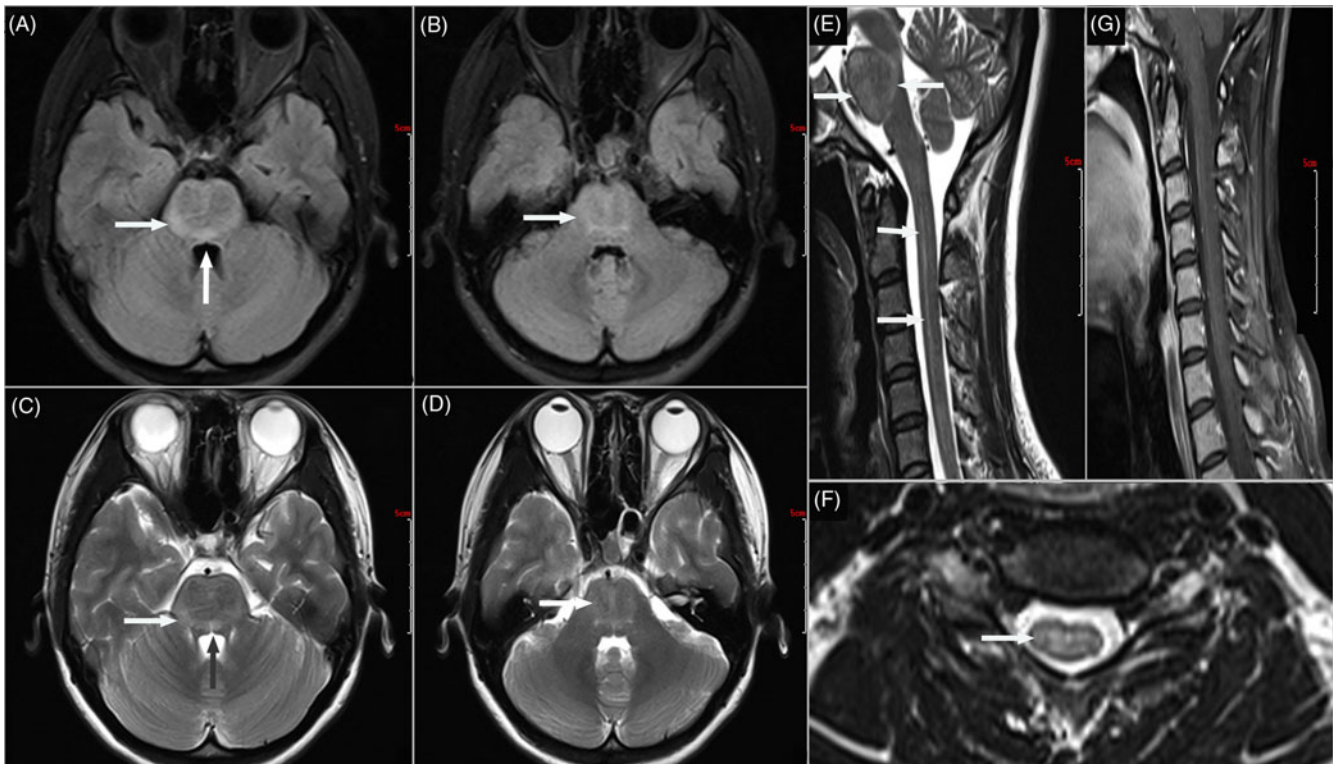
MR images obtained on the 10th day after upper respiratory tract infection. (A–D) FLAIR and T2-weighted axial brain MR images demonstrated multiple high-signal lesions in the brain stem (indicated by arrows). T2-weighted sagittal (E) and axial (F) cervical spine MR images demonstrated multiple high-signal lesions, which were dominant in the gray matter. (G) The post-contrast T1-weighted sagittal MRI demonstrated pathological enhancement within the cervical cord.
